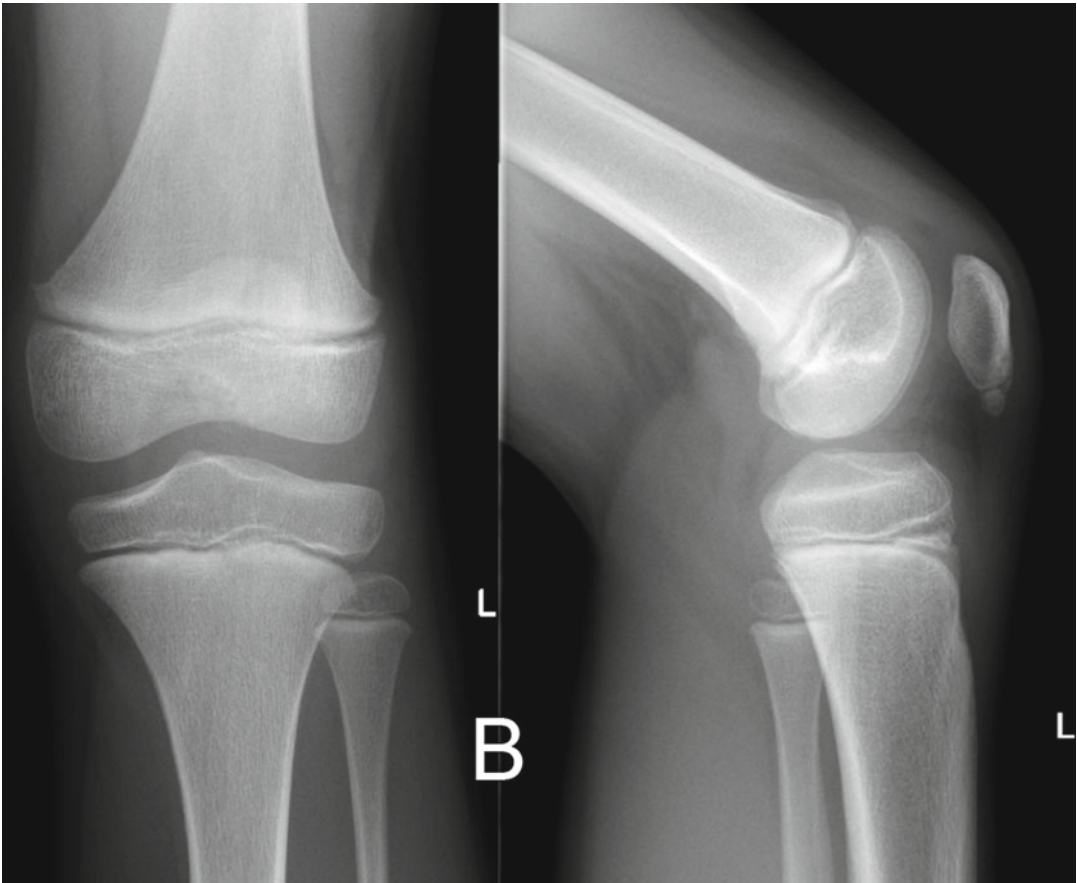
X-ray shows typical radiological situation of knee joint in a 6-year-old girl
